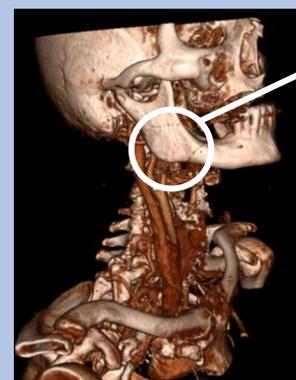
CT, 3D view of right artefact mimicking mandibular fracture.
